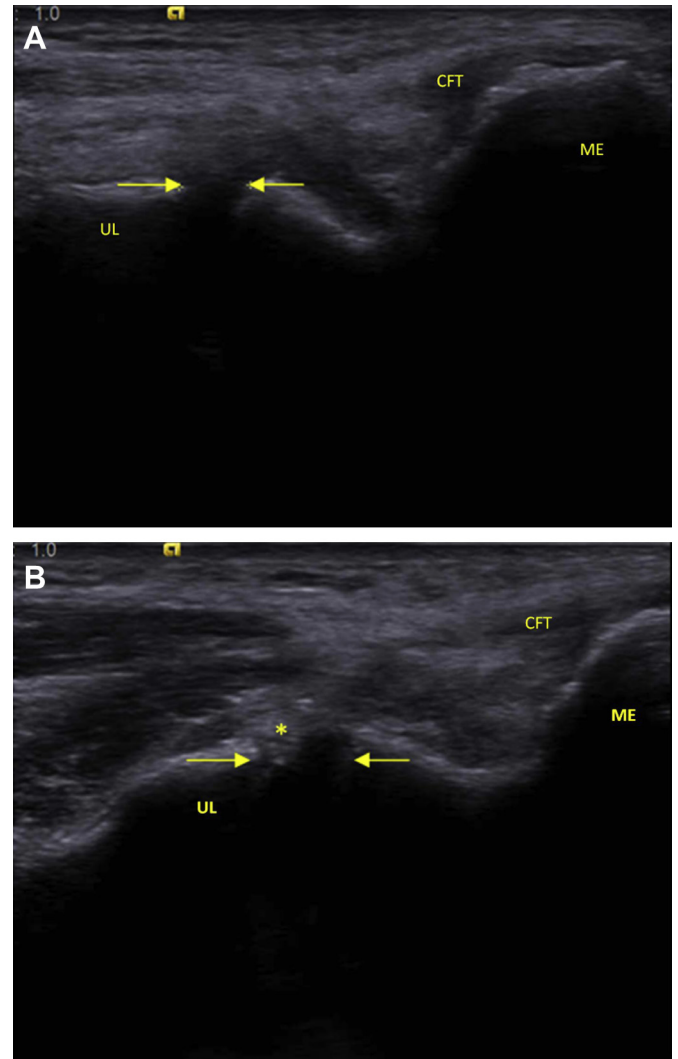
Follow-up coronal ultrasound scan 3 years later, scanning through the medial aspect of the elbow. (A) At rest, the left elbow shows the left medial collateral ligament with a joint space of 4.0 mm (arrows). (B) Under valgus stress the left elbow shows widening of the elbow joint to a width of 5.5 mm (between arrows). Heterogeneous hyperechogenicity (granulation tissue) in the area of the previous medial collateral ligament tear (star). CFT = common flexor tendon; ME = medial epicondyle; UL = ulnar bone.
